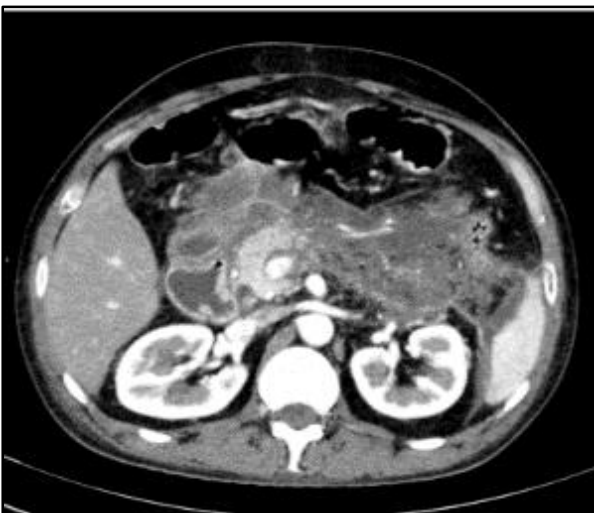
Acute Necrotising Pancreatitis. Axial Contrast-Enhanced CT Image Showing a Bulky Pancreas with Non-Enhancing Pancreatic Parenchyma Involving >50% of Pancreatic Parenchyma.
